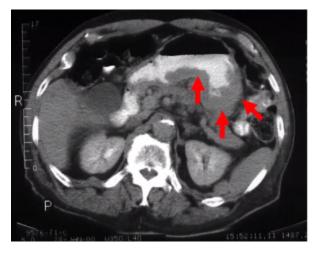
CT scan showing a fairly obvious cancer in the posterior aspect of the stomach, as a large fungating lesion.
